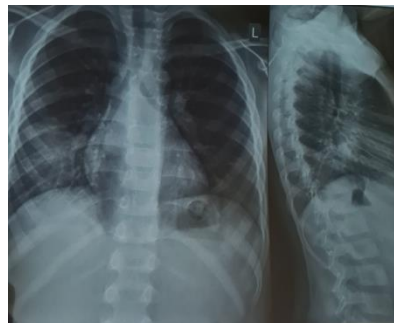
Chest X-ray 1 week after therapy: no improvement of the finding
